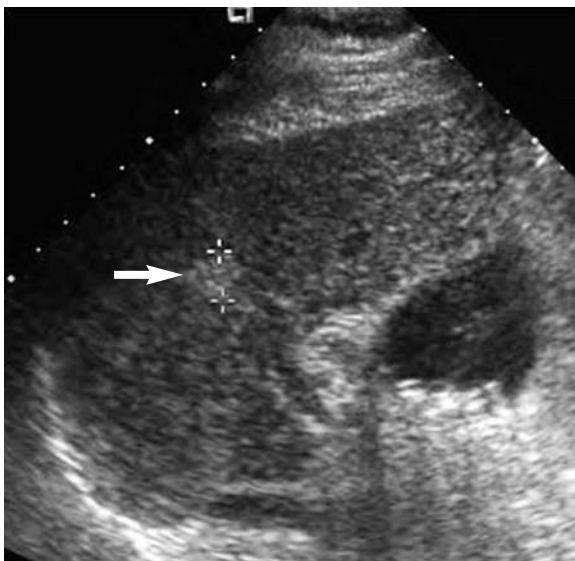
A small 1.3-cm mass (*arrow*) identified in an at-risk patient during ultrasonographic screening for hepatocellular carcinoma.
